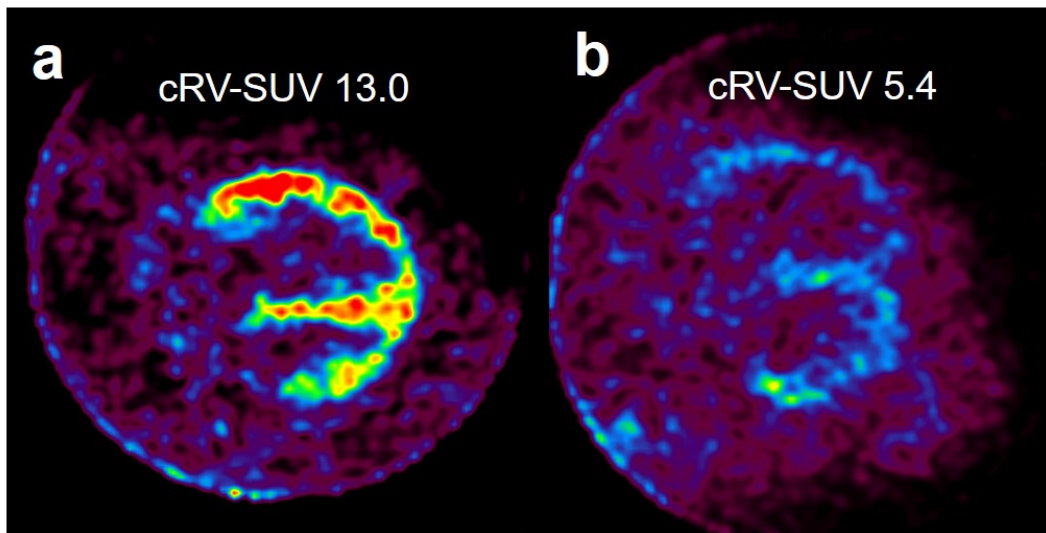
Evaluation of Right Ventricular Glucose Metabolism by FDG-PET in PH Patients
